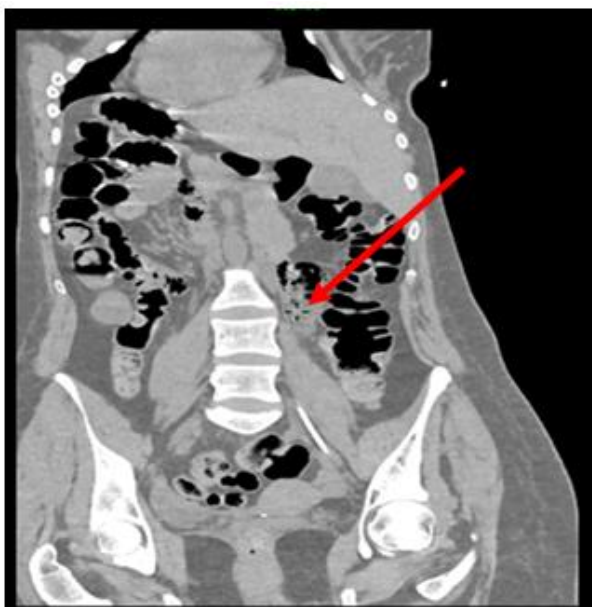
CT image showing a jejunal tumor process
